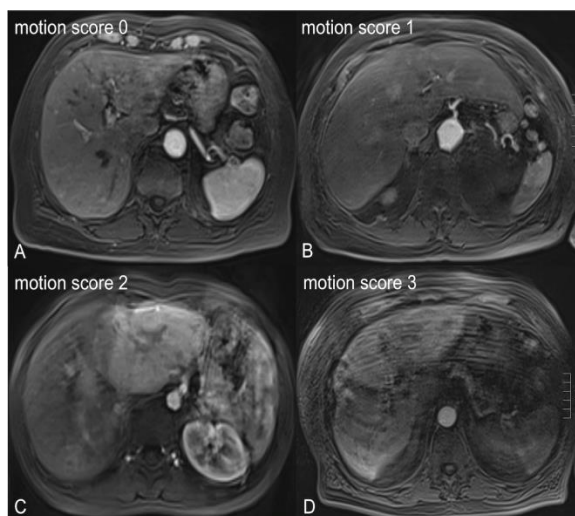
Categorization of motion artifacts caused by acute transient dyspnea in MR imaging. Axial T1-weighted transverse gradient-echo MR images directly following intravenous gadoxetate application exclusively seen in arterial phases show motion score 0 (A), 1 (B), 2 (C) and 3 (D), respectively. Diagnostic image quality is reduced especially in figures C and D.
